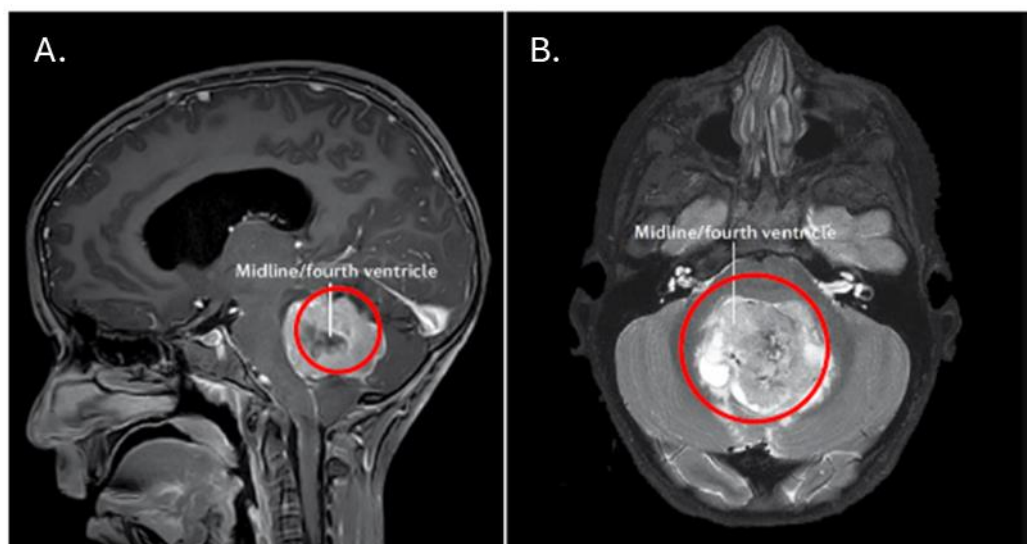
Cranial MRI scan showing tumour location of a patient with MB. A) Sagittal and B) transverse plane of cranial MRI showing tumour localisation to the midline/fourth ventricle. Adapted from Northcott *et al.*
